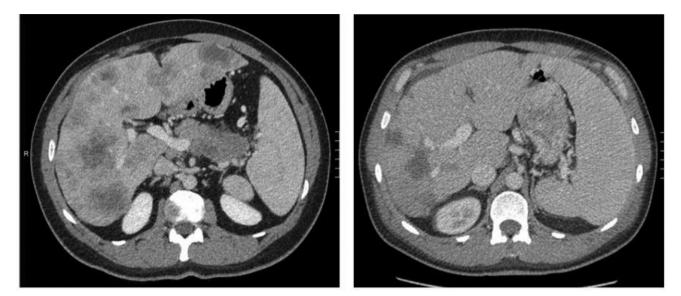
Abdominal CT scans at baseline (L) and after 6 months of treatment (R).
